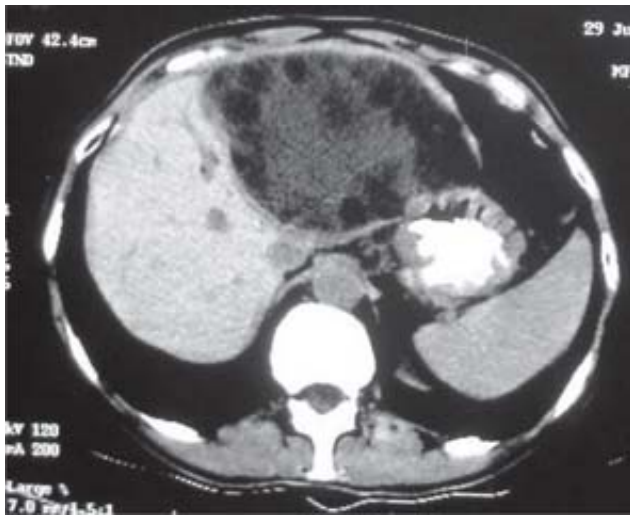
Contrast enhanced computed tomography scan showing a giant hydatid cyst occupying almost the entire left liver lobe. It contains inhomogeneous fluid and several daughter cysts.
